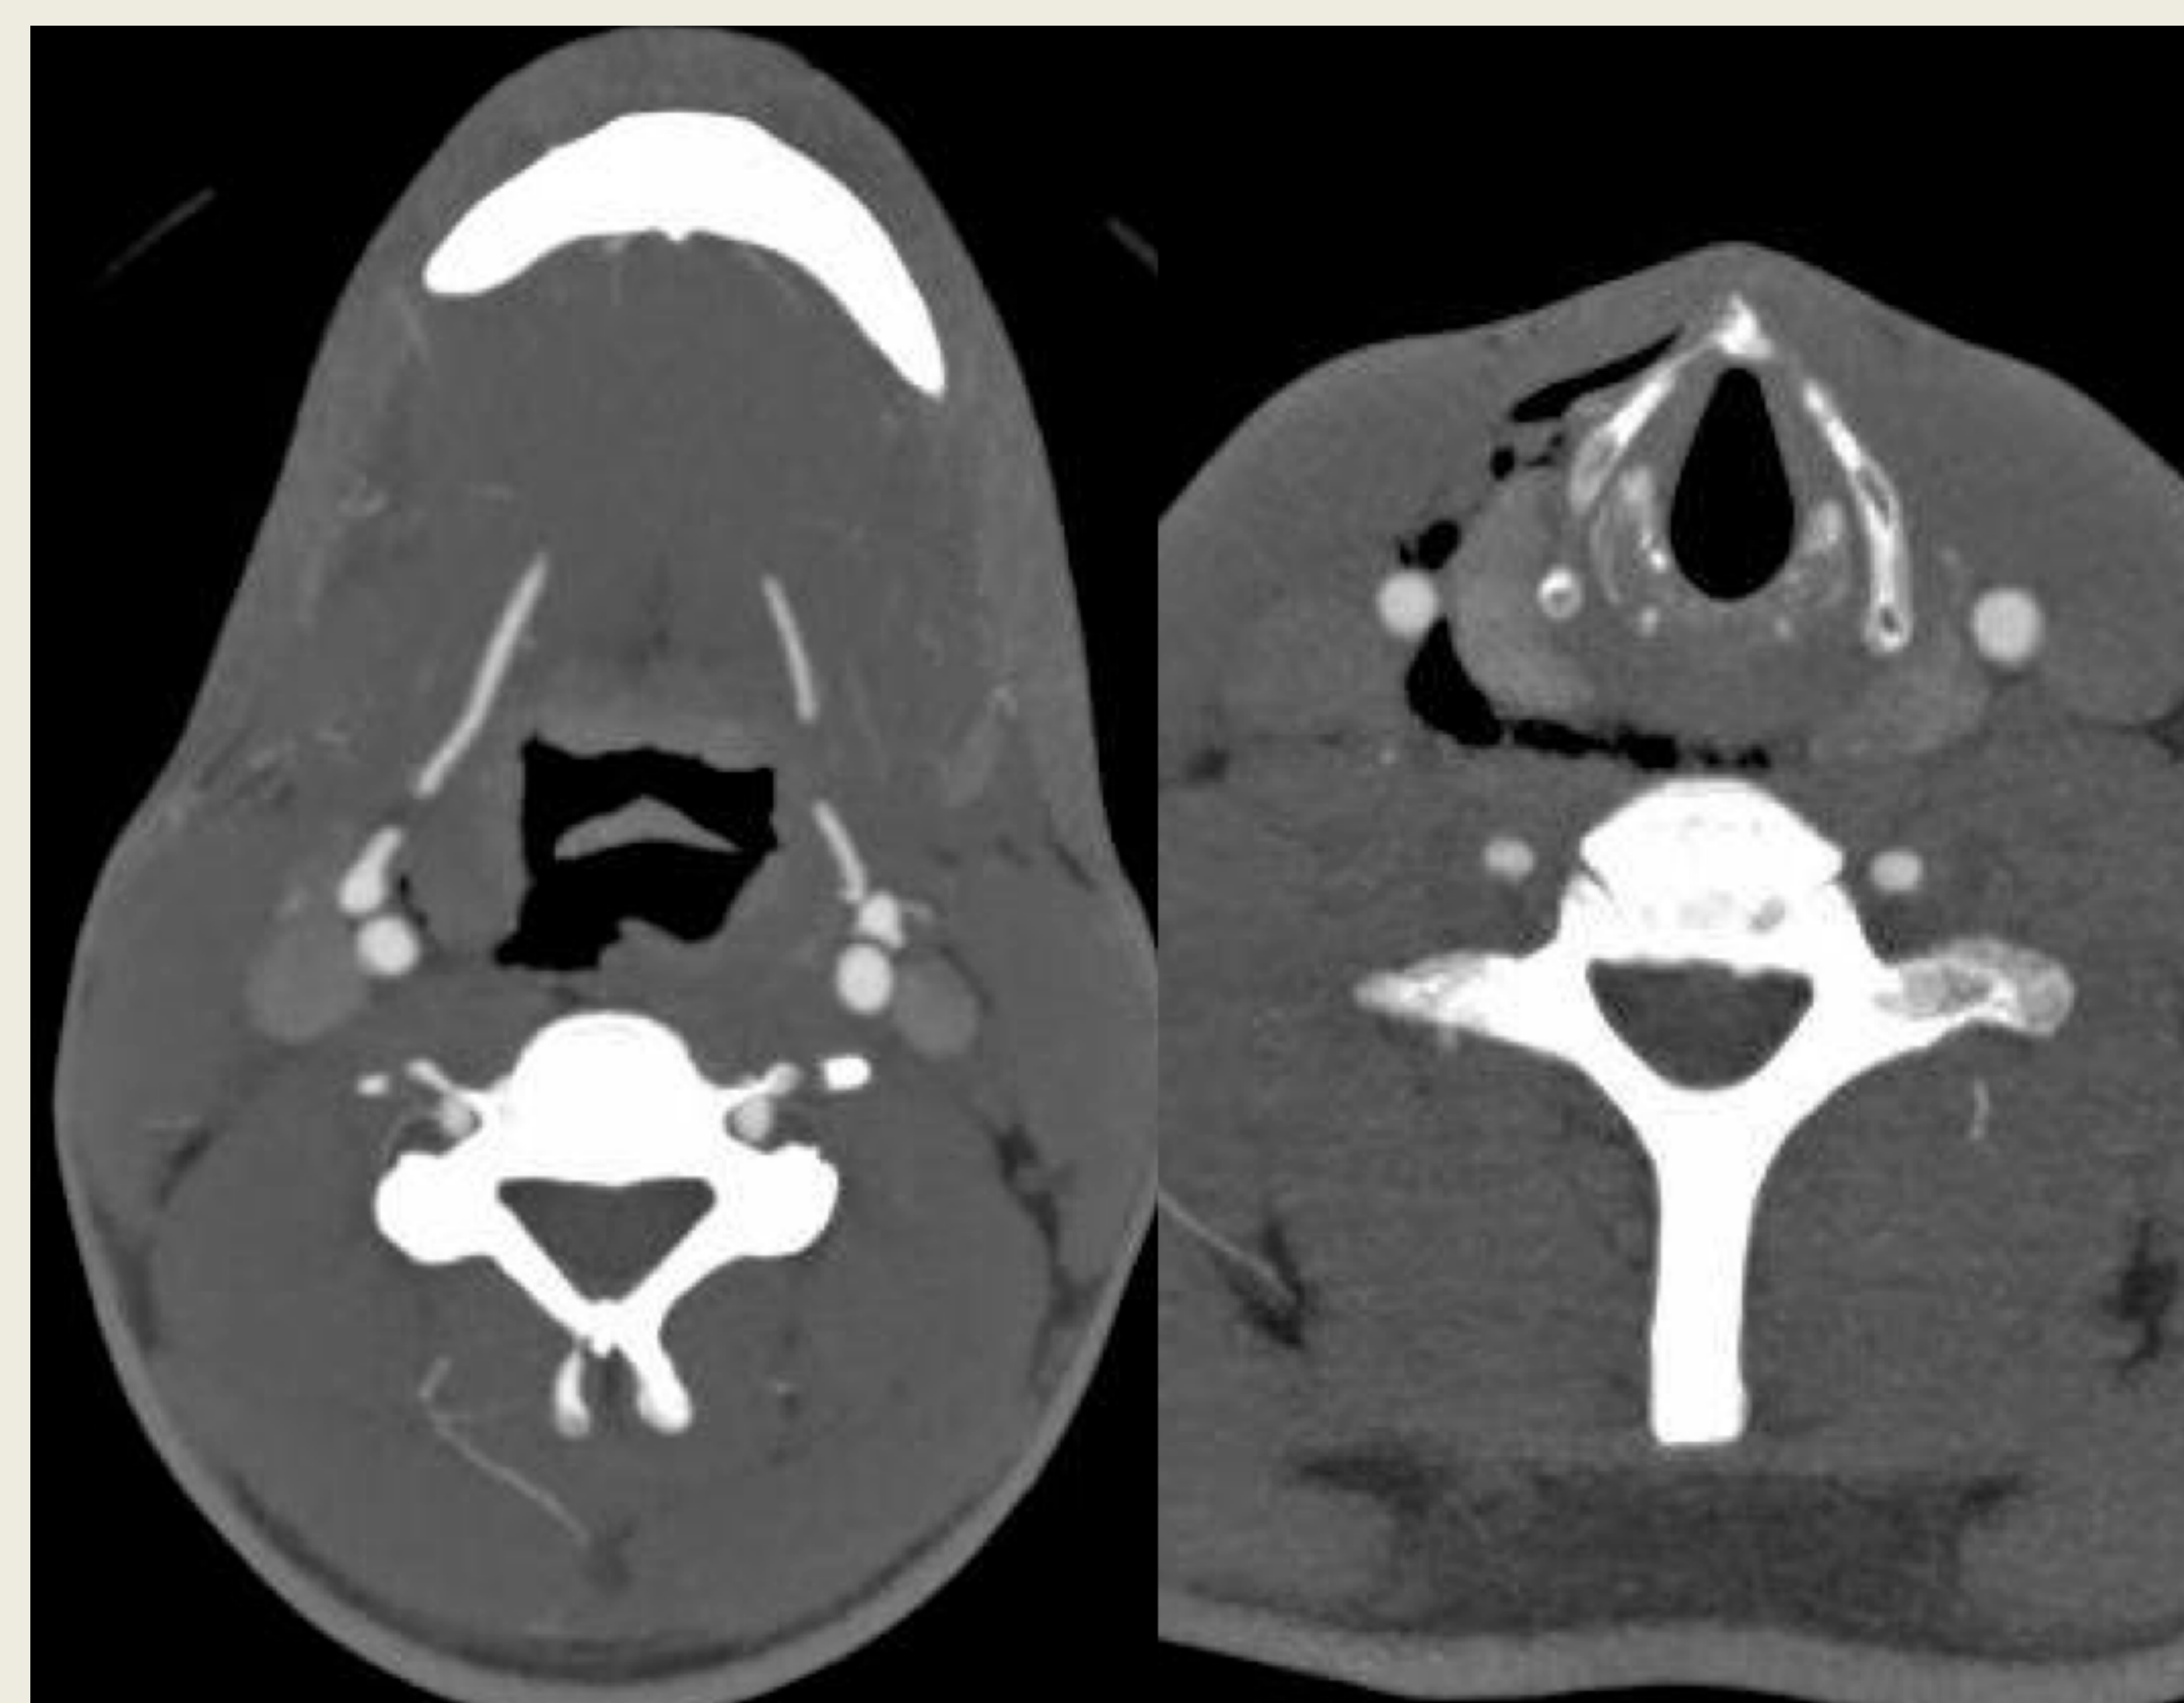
CT neck with contrast showing disruption of the right posterior pharyngeal wall with soft tissue air dissecting down the retropharyngeal space and extending anteriorly between the carotid sheath and thyroid cartilage
